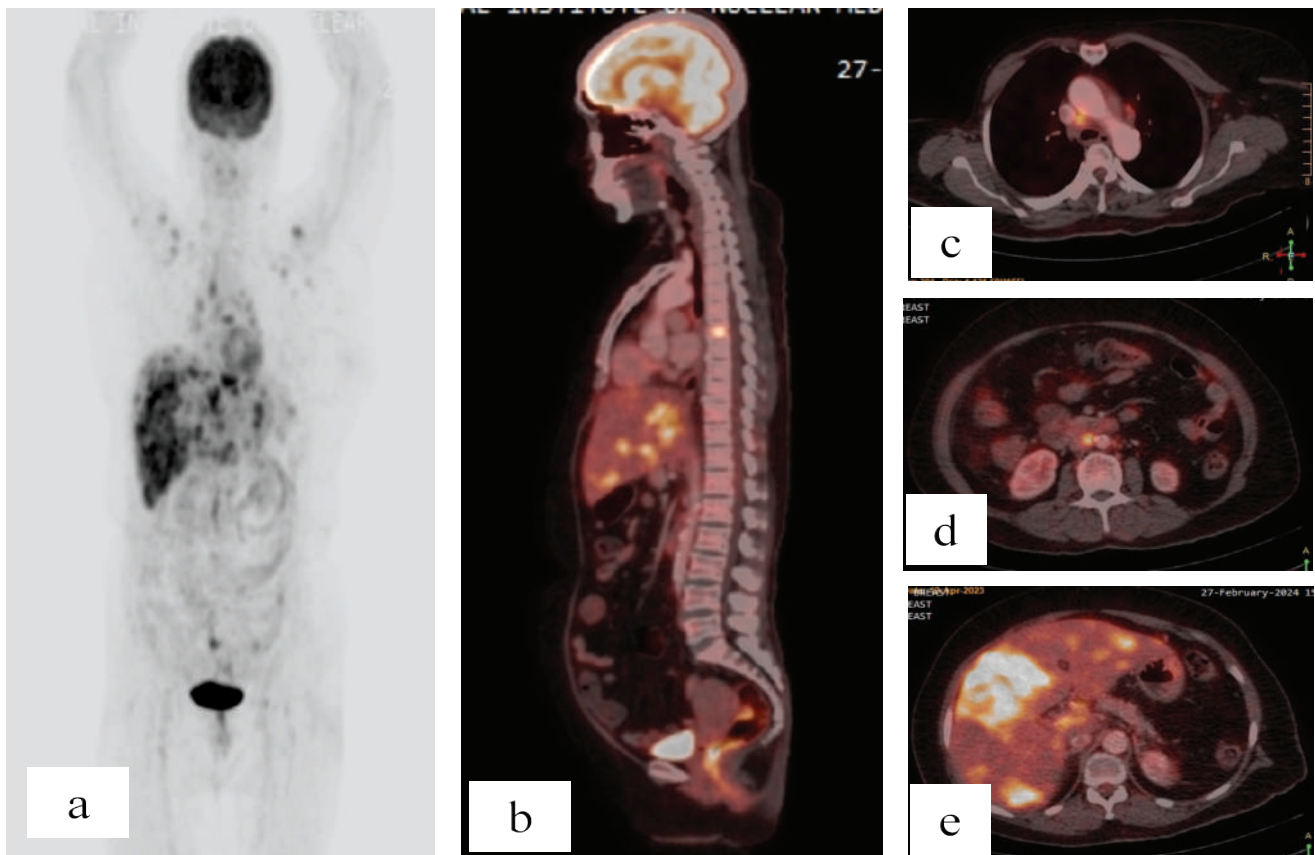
18F-FDG PET-CT scan image of a 60 years old female with tripple positive breast carcinoma patient. Came for follow up evaluation after 18 months of completion of MRM with axillary clearance followed by 8 cycles of chemotherapy. PET-CT scan showing hypermetabolic mediastinal © and abdominal lymph nodes (d), multiple hypodense lesions in both lobes of liver (e) and FDG avid sclerotic lesions in spine (b) suggesting metastases.
